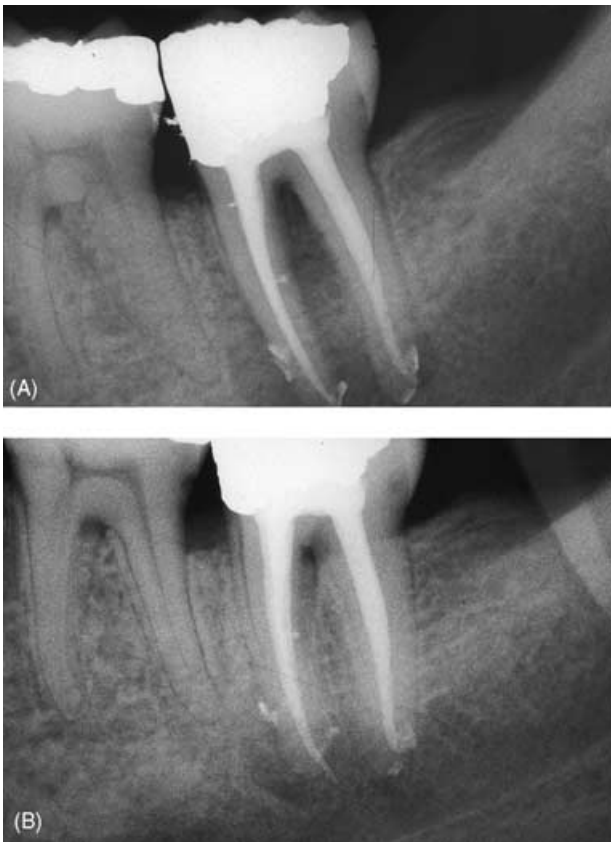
(A) Postoperative radiograph showing multiple lateral canals in a mandibular second molar with apical and furcal radiolucencies. (B) One-year follow-up radiograph showing bony healing.
